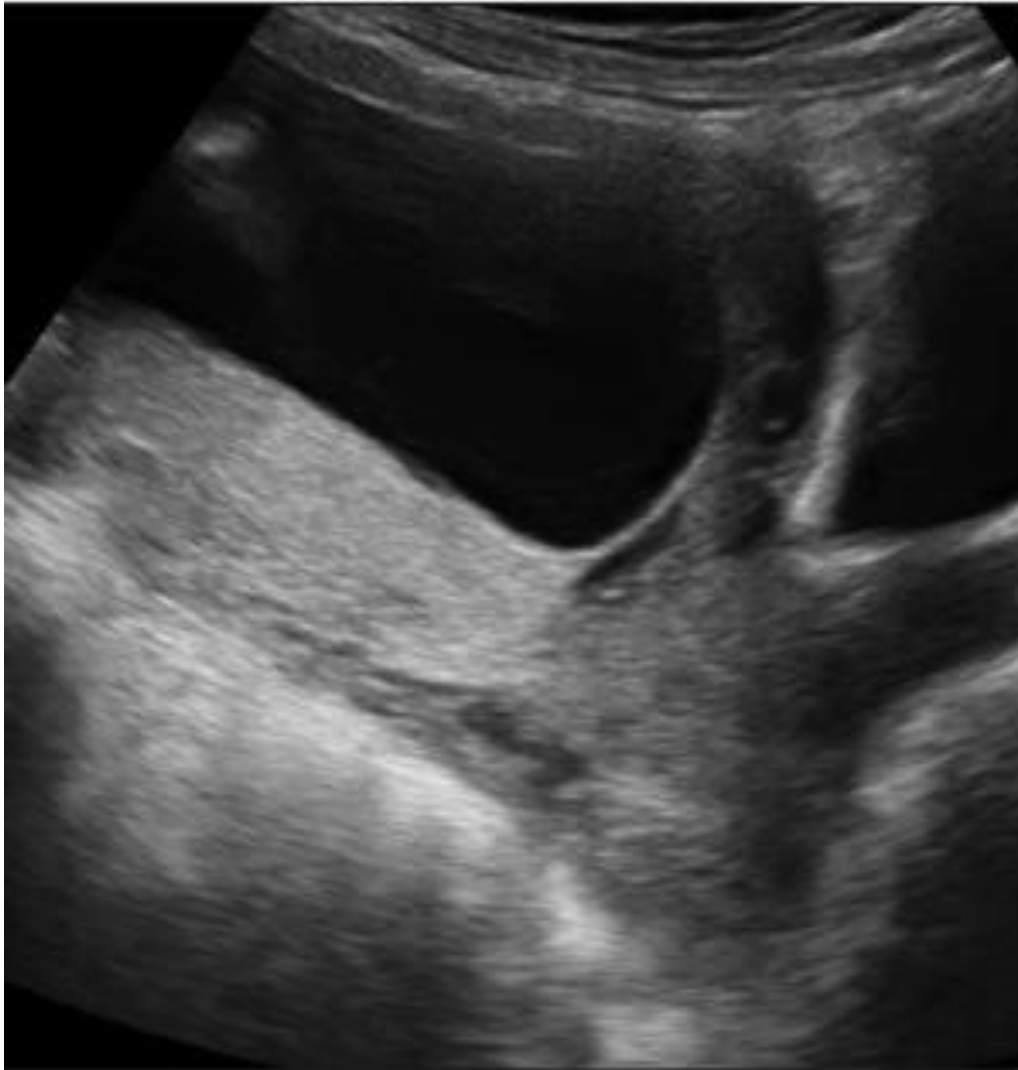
17-week ultrasound image of a low-lying placenta
